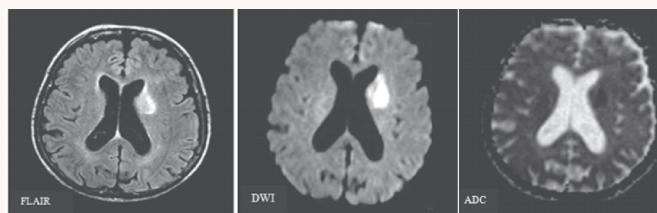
A 72-year-old female presented with mental and language disturbance, since 20 days. Enhancing lesion, restricted diffusion on DWI and ADC. (Diagnosis: Lymphoma).
